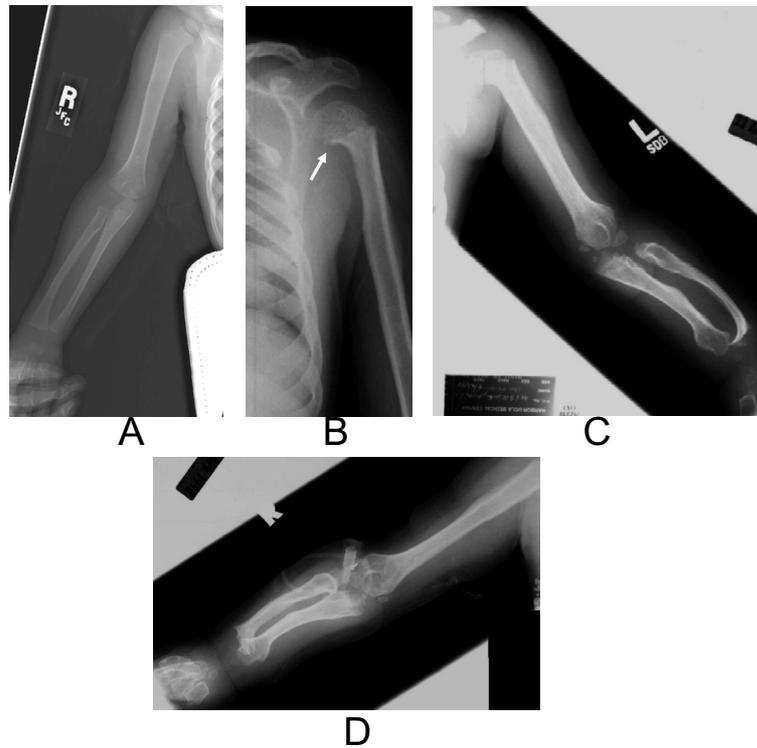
Manifestations of dysostosis multiplex in long bones (humerus, radius and ulna). Radiographs showing normal humerus, radius and ulna (A), and humerus, radius and ulna of MPS patients with (B) proximal humeral notching (arrow), (C) humeral notching, distal radial and ulnar shortening with thick diaphyses (mesomelia), and (D) mesomelia and distal hypoplasia of the radius and ulna.
